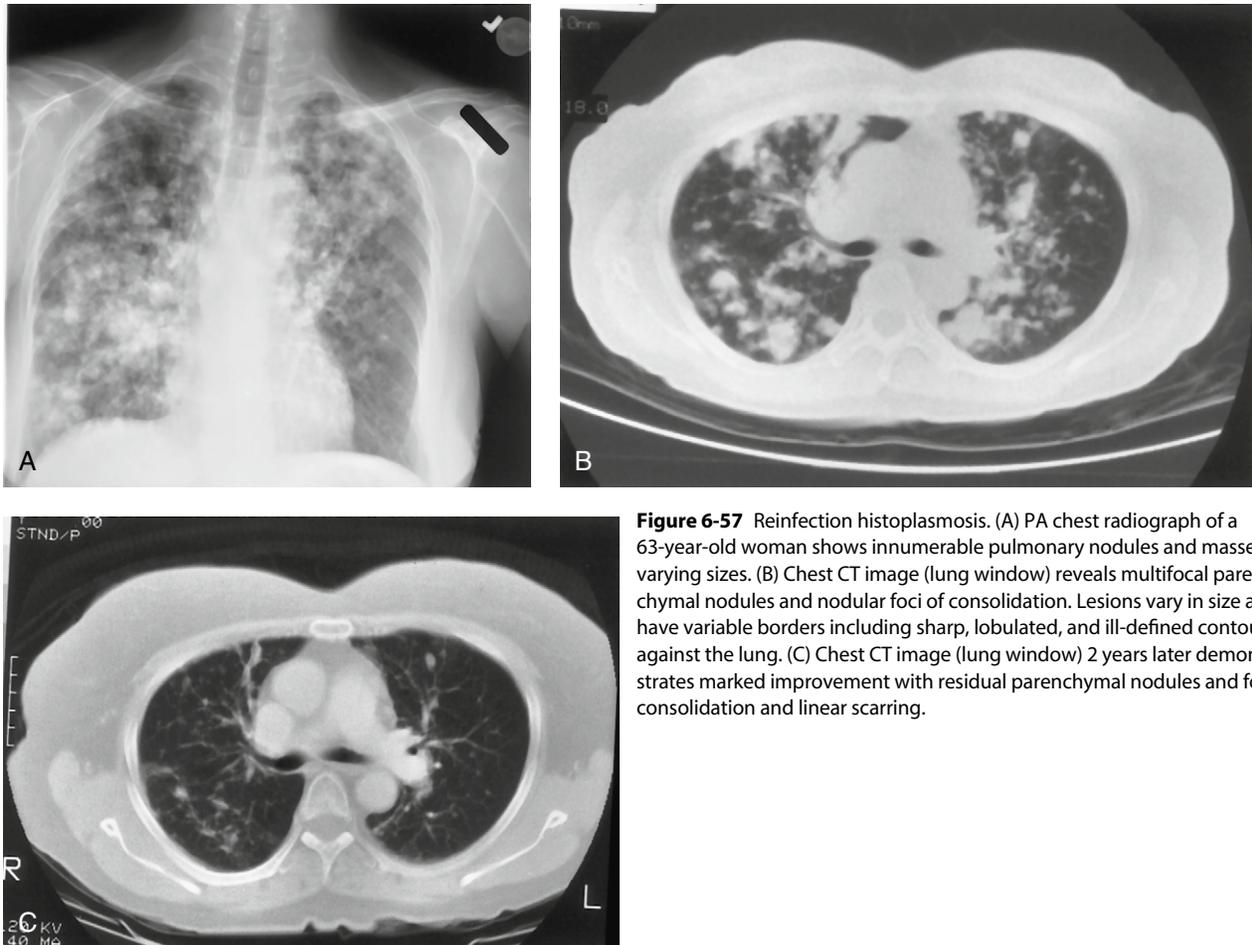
Reinfection histoplasmosis. (A) PA chest radiograph of a 63-year-old woman shows innumerable pulmonary nodules and masses of varying sizes. (B) Chest CT image (lung window) reveals multifocal parenchymal nodules and nodular foci of consolidation. Lesions vary in size and have variable borders including sharp, lobulated, and ill-defined contours against the lung. (C) Chest CT image (lung window) 2 years later demonstrates marked improvement with residual parenchymal nodules and foci of consolidation and linear scarring.
